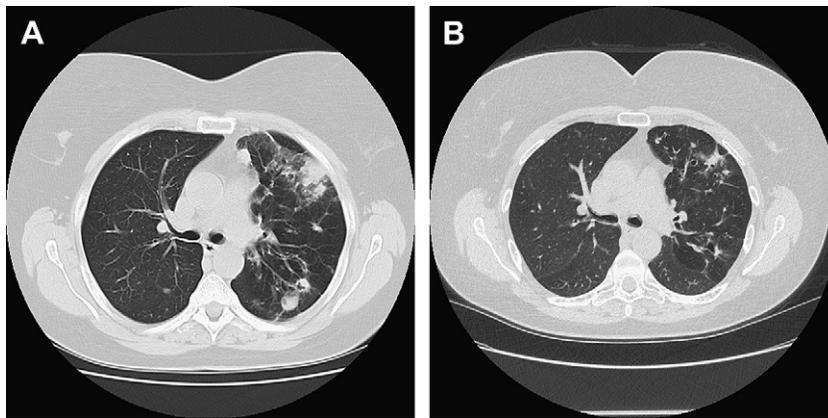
(A) HRCT image of a 60-year-old woman with bronchiectasis diagnosed with *M avium* complex (MAC) lung disease before initiation of therapy, demonstrating primarily large nodular densities. (B) Comparable HRCT image after successful treatment of MAC lung disease with a macrolide-based regimen for a duration including 12 months of sputum AFB-culture negativity while on therapy.
